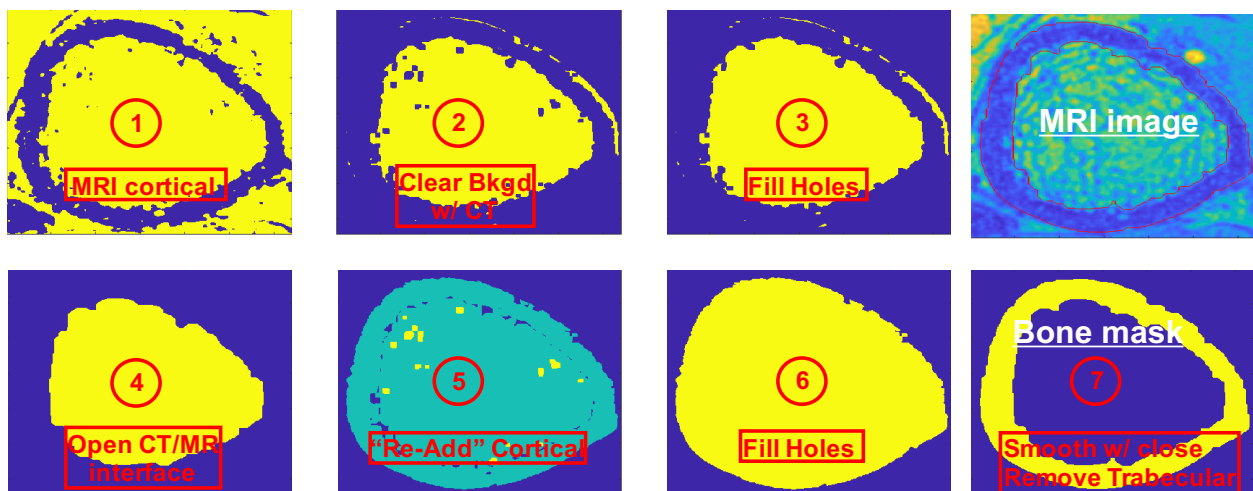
Steps in the MRI bone mask algorithm
